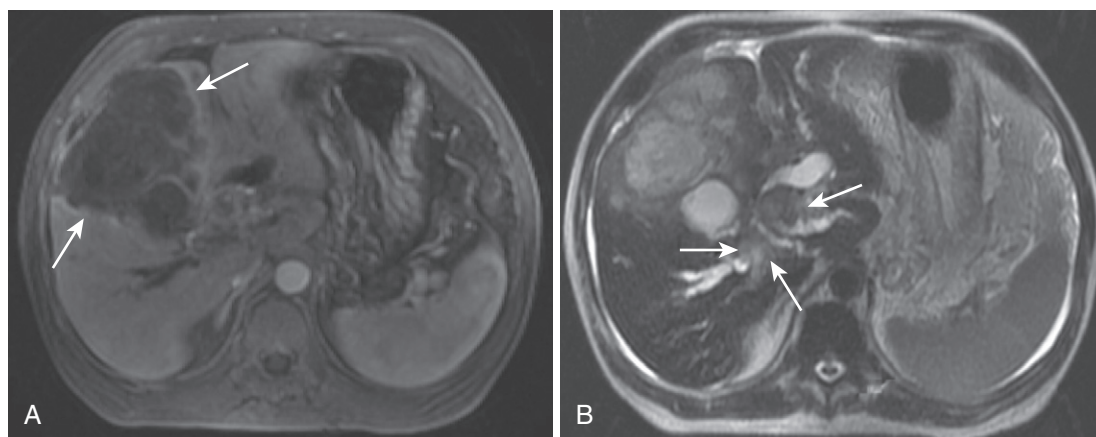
Liver infarct associated with malignant vascular invasion. The postcontrast image (A) shows a roughly wedge-shaped geographic nonenhancing lesion in the anterior and medial hepatic segments (*arrows*), thought to represent a liver infarct in a patient with hilar cholangiocarcinoma, which is better seen on the T2-weighted image (*arrows* in B) at the confluence of the dilated intrahepatic ducts.
